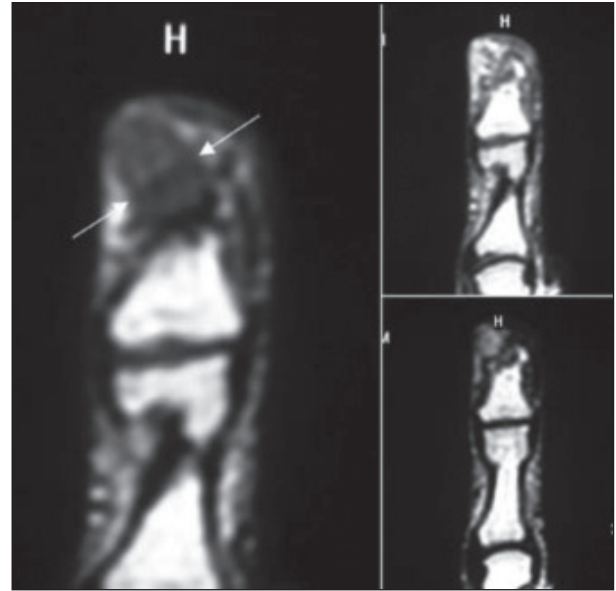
MRI of the lesion in coronal plane. Two adjacent soft tissue masses having the same signal characteristics were seen; the lesions are separated with a hypointense line (between the arrows). Both tumors had low intensity in the T1-weighted image (left) and intermediate intensity in the T2-weighted image (lower right). After the administration of intravenous contrast material, heterogeneous enhancement is seen (upper right).
